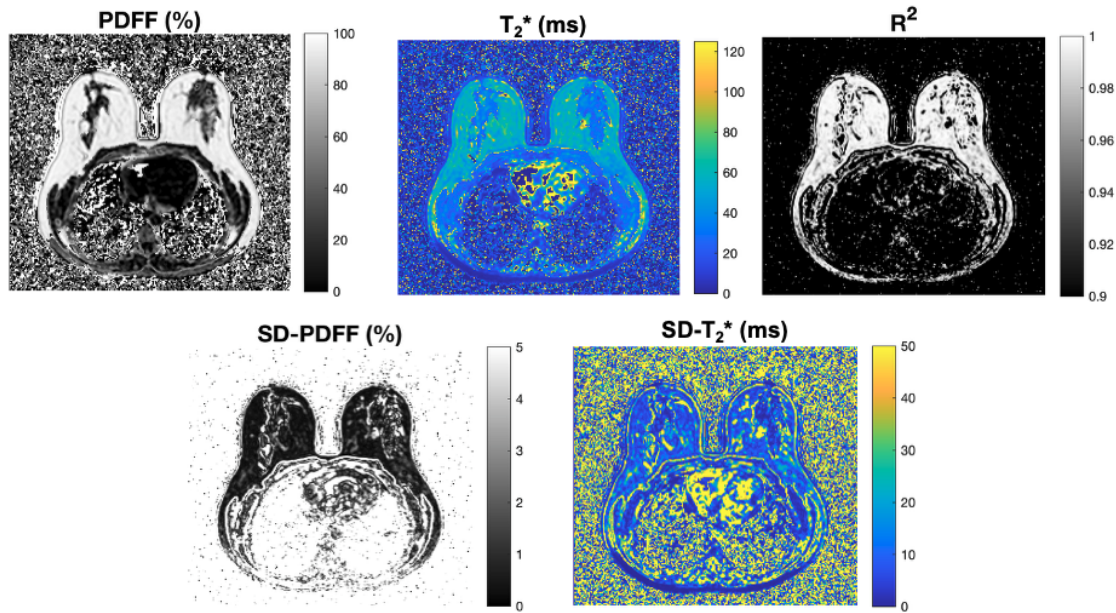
Example PDFF, T_2^* , R^2 , SD-PDFF, and SD- T_2^* maps at the central slice of the GRE acquisition for one participant. Example quantitative breast maps, shown at the central slice of a 3D GRE acquisition. Top left: Proton Density Fat Fraction (PDFF) map, with units of percentage, reflecting tissue fat content at each pixel, top centre: T_2^* map, with units of milliseconds (ms), reflecting the transverse relaxation time at each pixel, top right: the R^2 map, showing the goodness-of-fit of the CSE-MRI signal model to the acquired data, bottom: SD-PDFF and SD- T_2^* maps, reflecting the uncertainty in measurement of each of these metrics at each pixel.
